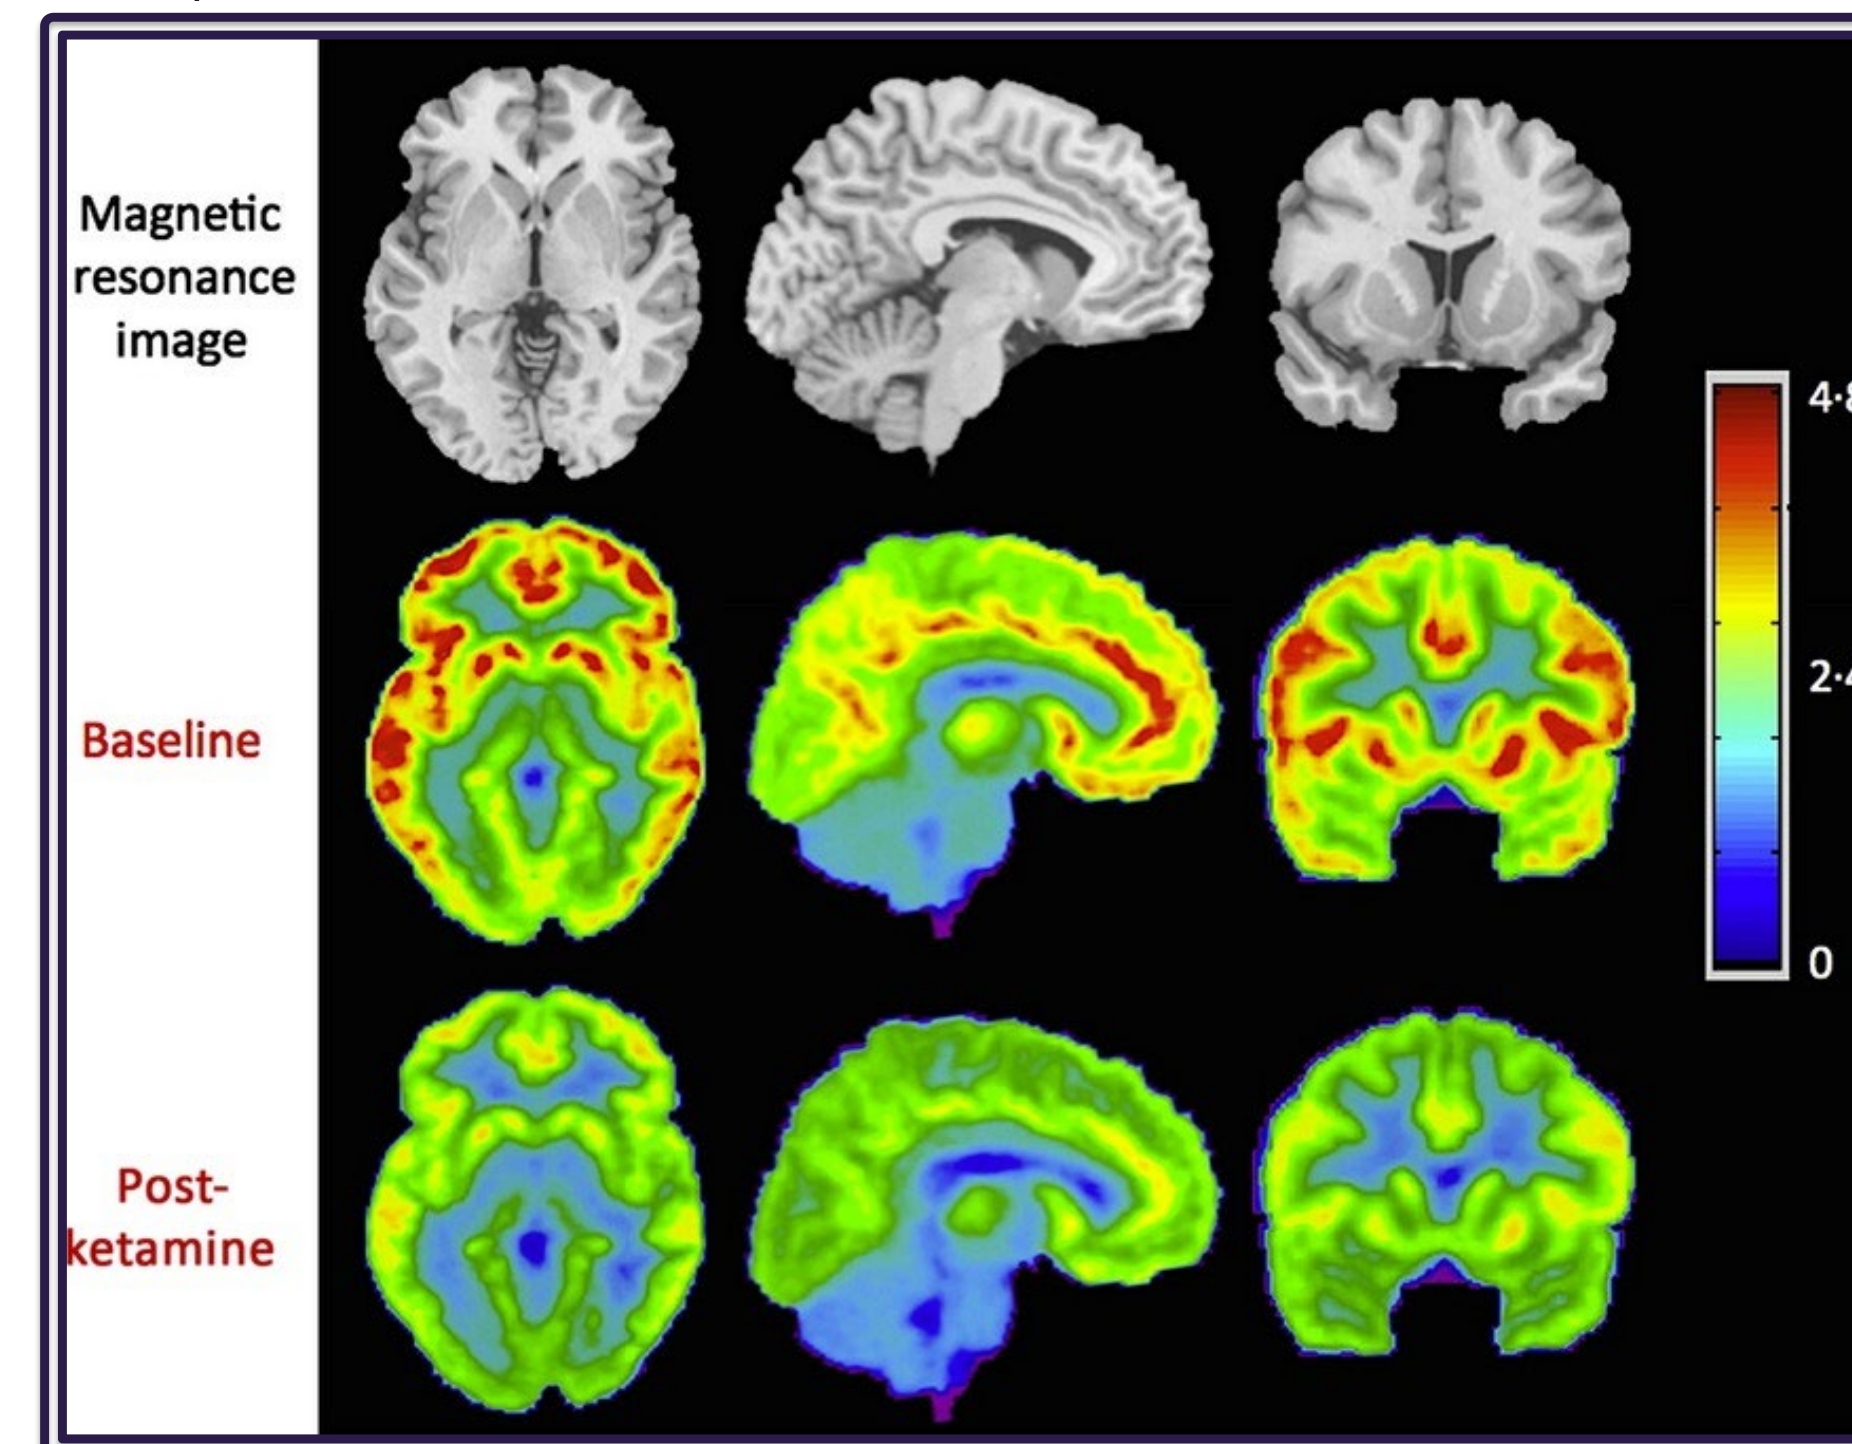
Image shows magnetic resonance imaging (MRI) and brain activity before and after ketamine treatment. People with MDD have hyperactive brains, as shown by the red in the baseline. Once treatment was administered, all red is depleted and the brain then functions at a lower power. (Drewniny et. al 2014).
